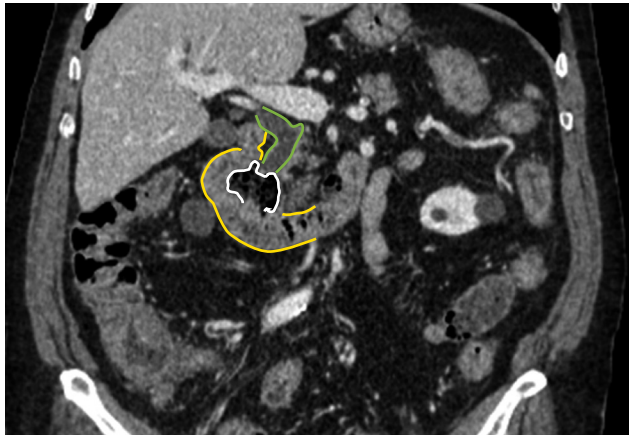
Coronal reformat of contrast-enhanced CT shows the presence of a diverticulum (38 x 24 mm, white line) in the second portion of the duodenum (yellow lines) and common bile duct dilation (green lines). The duodenal diverticulum is well depicted as a gas-containing sac protruding from the inner wall of the duodenum.
